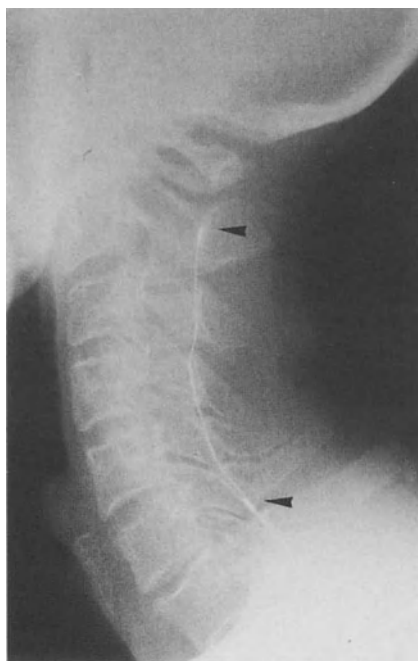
Roentgenogram showing electrodes (*arrowheads*) inserted into the epidural space of the cervical spinal cord
